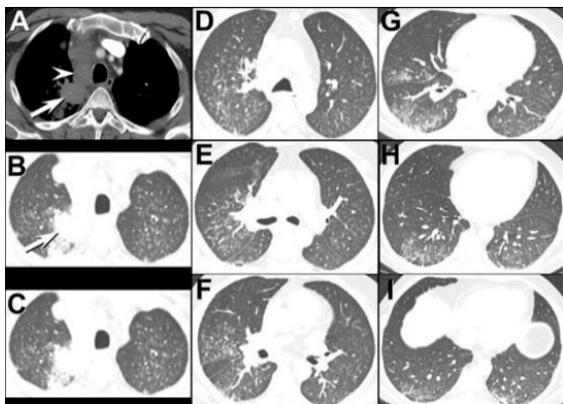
Axial enhanced CT pulmonary angiography in the upper (A-C), Mid (D-F), and lower (G-I) lungs. Click [here](#) to open Figure 2 in a new, enlarged window. Click [here](#) to open a video of Figure 2.
